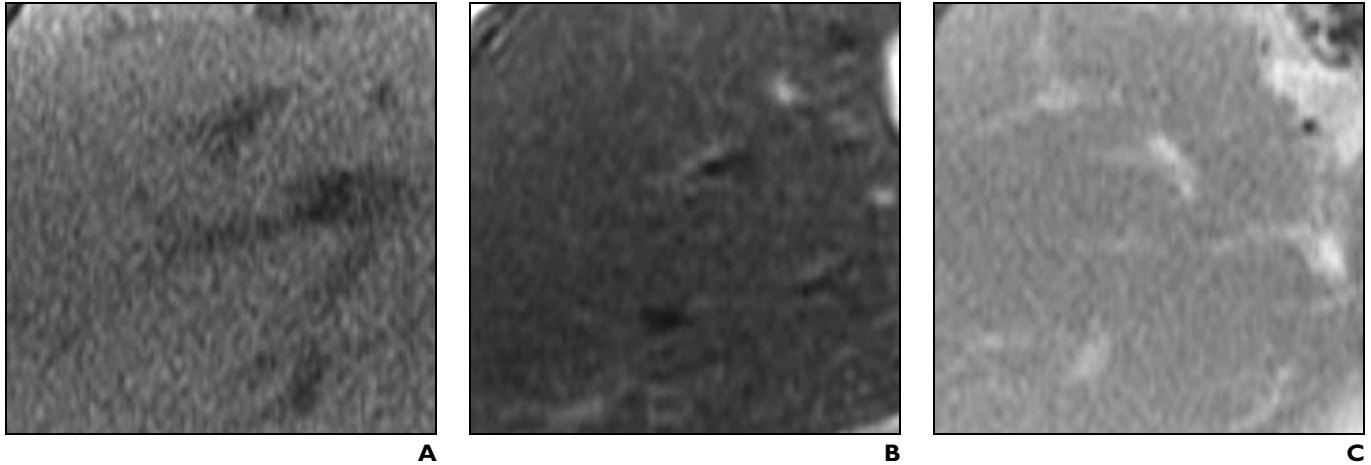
73-year-old man without hepatitis (F0 on Desmet scale [1]) who underwent partial hepatectomy for solitary liver metastasis from ascending colon cancer. A–C, T1-weighted spoiled gradient-recalled echo axial image (TR/TE, 150/1.6) (A), T2-weighted fast spin-echo axial image (4,286/80) (B), and gadolinium-enhanced equilibrium phase axial image (150/1.6) (C) show homogeneous signal intensity in liver parenchyma.
